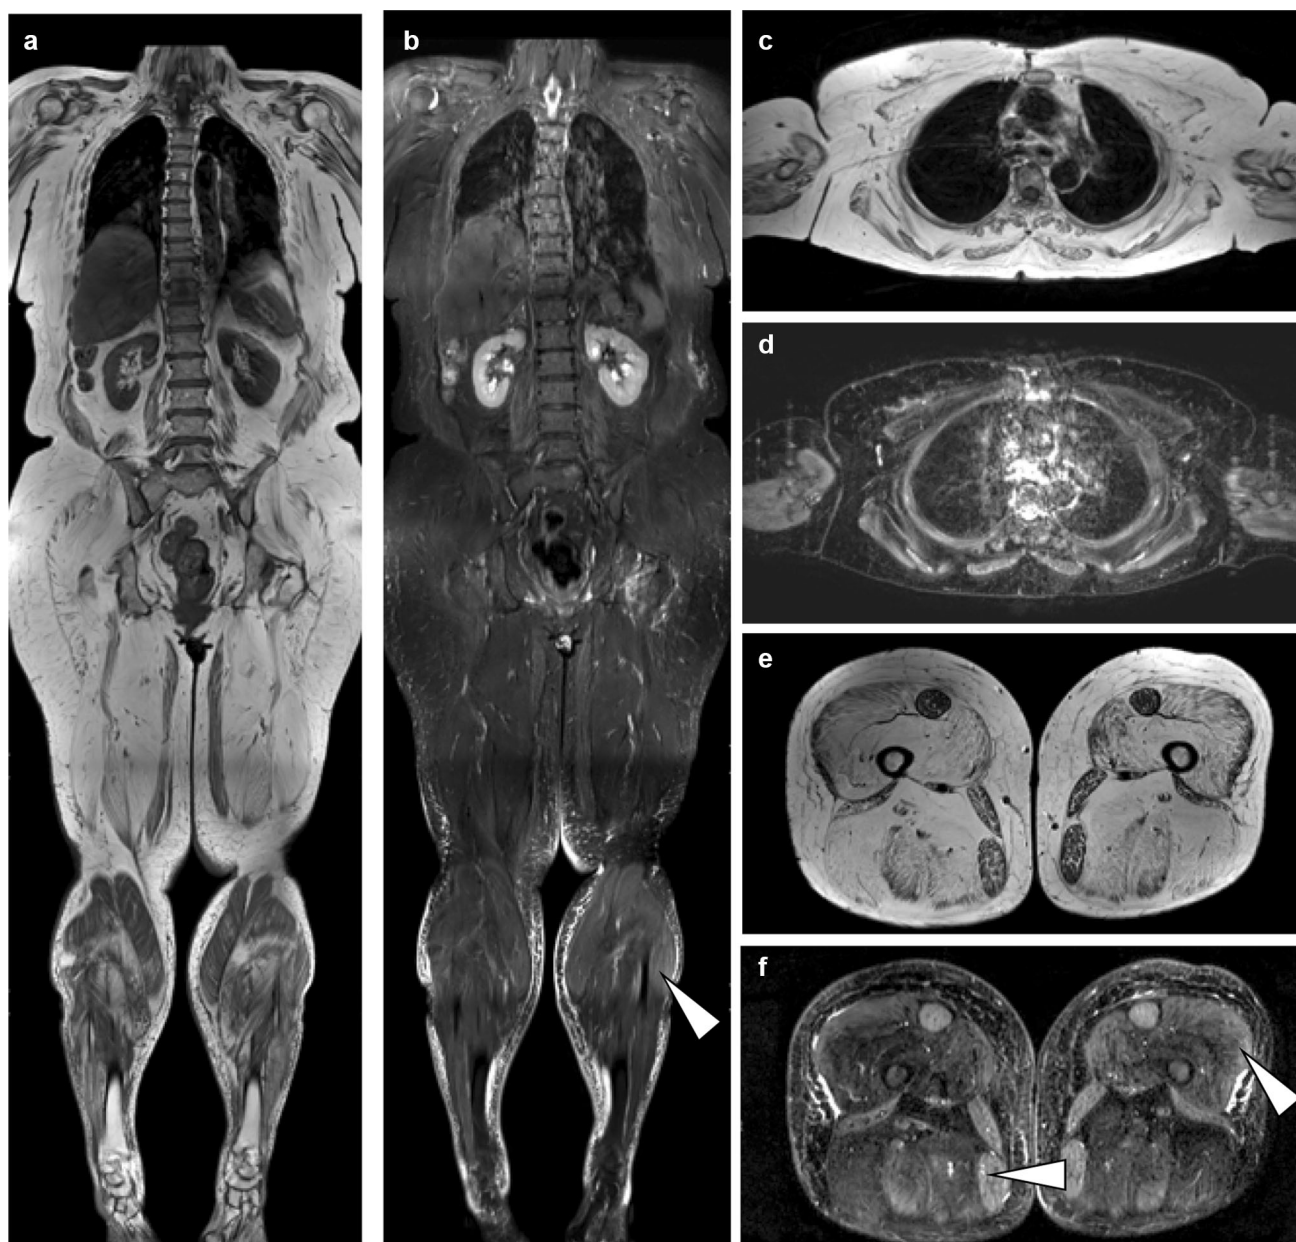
WBMRI images in a 73-year-old female woman with longstanding polymyositis (more than 30 years) presenting with diffuse muscle weakness, dysphagia and dyspnea. Coronal T1 (a) and STIR (b) MR images show severe atrophy and fatty involution of multiple muscles with predominating trunk and thigh involvement.
